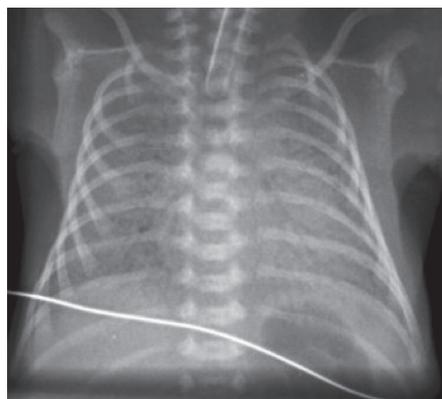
Chest radiograph of a premature baby with severe RDS. Shown are diffuse reticulo-granular opacities obscuring the cardiac silhouette and air bronchograms.
